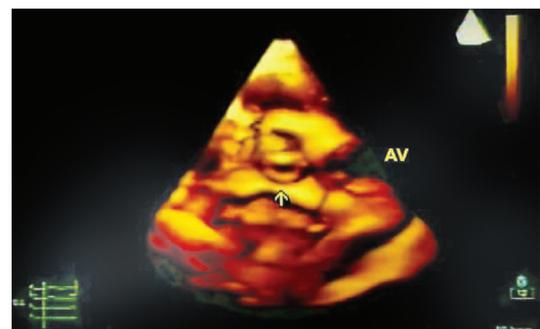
Live/real time three-dimensional transthoracic echocardiography. Arrow points to severe bicuspid AV stenosis. AV=aortic valve.
